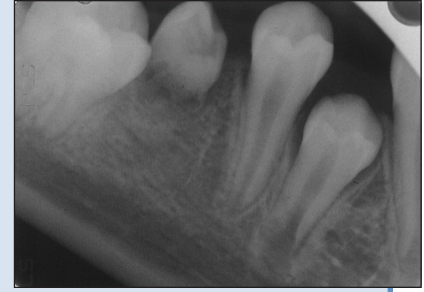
Periapical radiograph of the supplemental premolar taken 6 months after autotransplantation shows alveolar healing.
